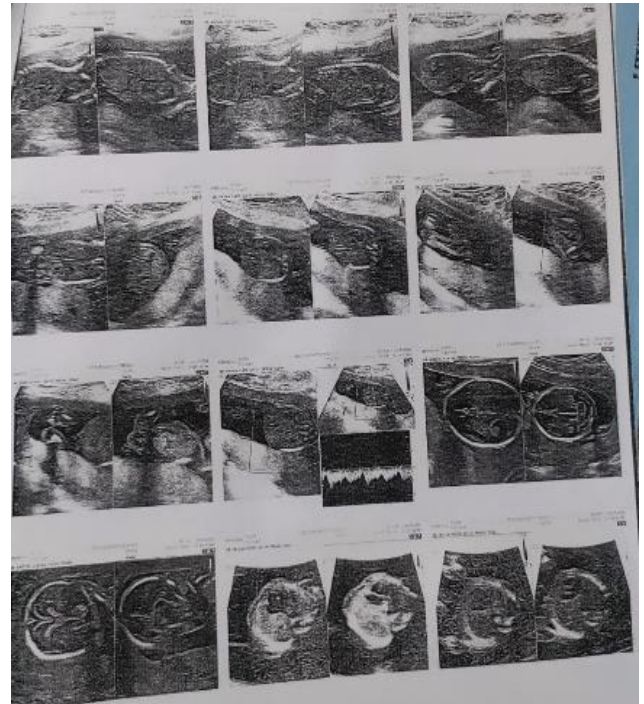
The prenatal ultrasound scan report.
